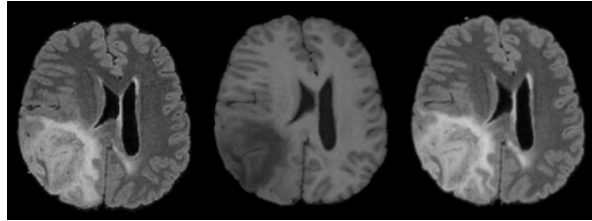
The rigid registration with 6 DOF of anatomical images of T_1 and FLAIR implemented in the MATLAB script `register_files_affine` [101] that is a part of BrainSuite software package (a reference image: T_1 and a moving image: FLAIR), brain images displayed in the axial plane. On the left: the skull stripped FLAIR image, in the middle: the skull stripped T_1 image, on the right: the final fused image.
